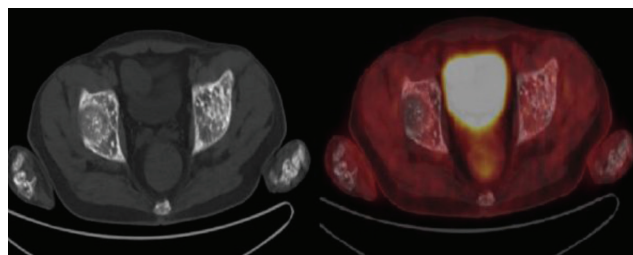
Sclerotic lesions with no increased FDG uptake in bilateral acetabulum, femoral head and phalanges in PET/CT
